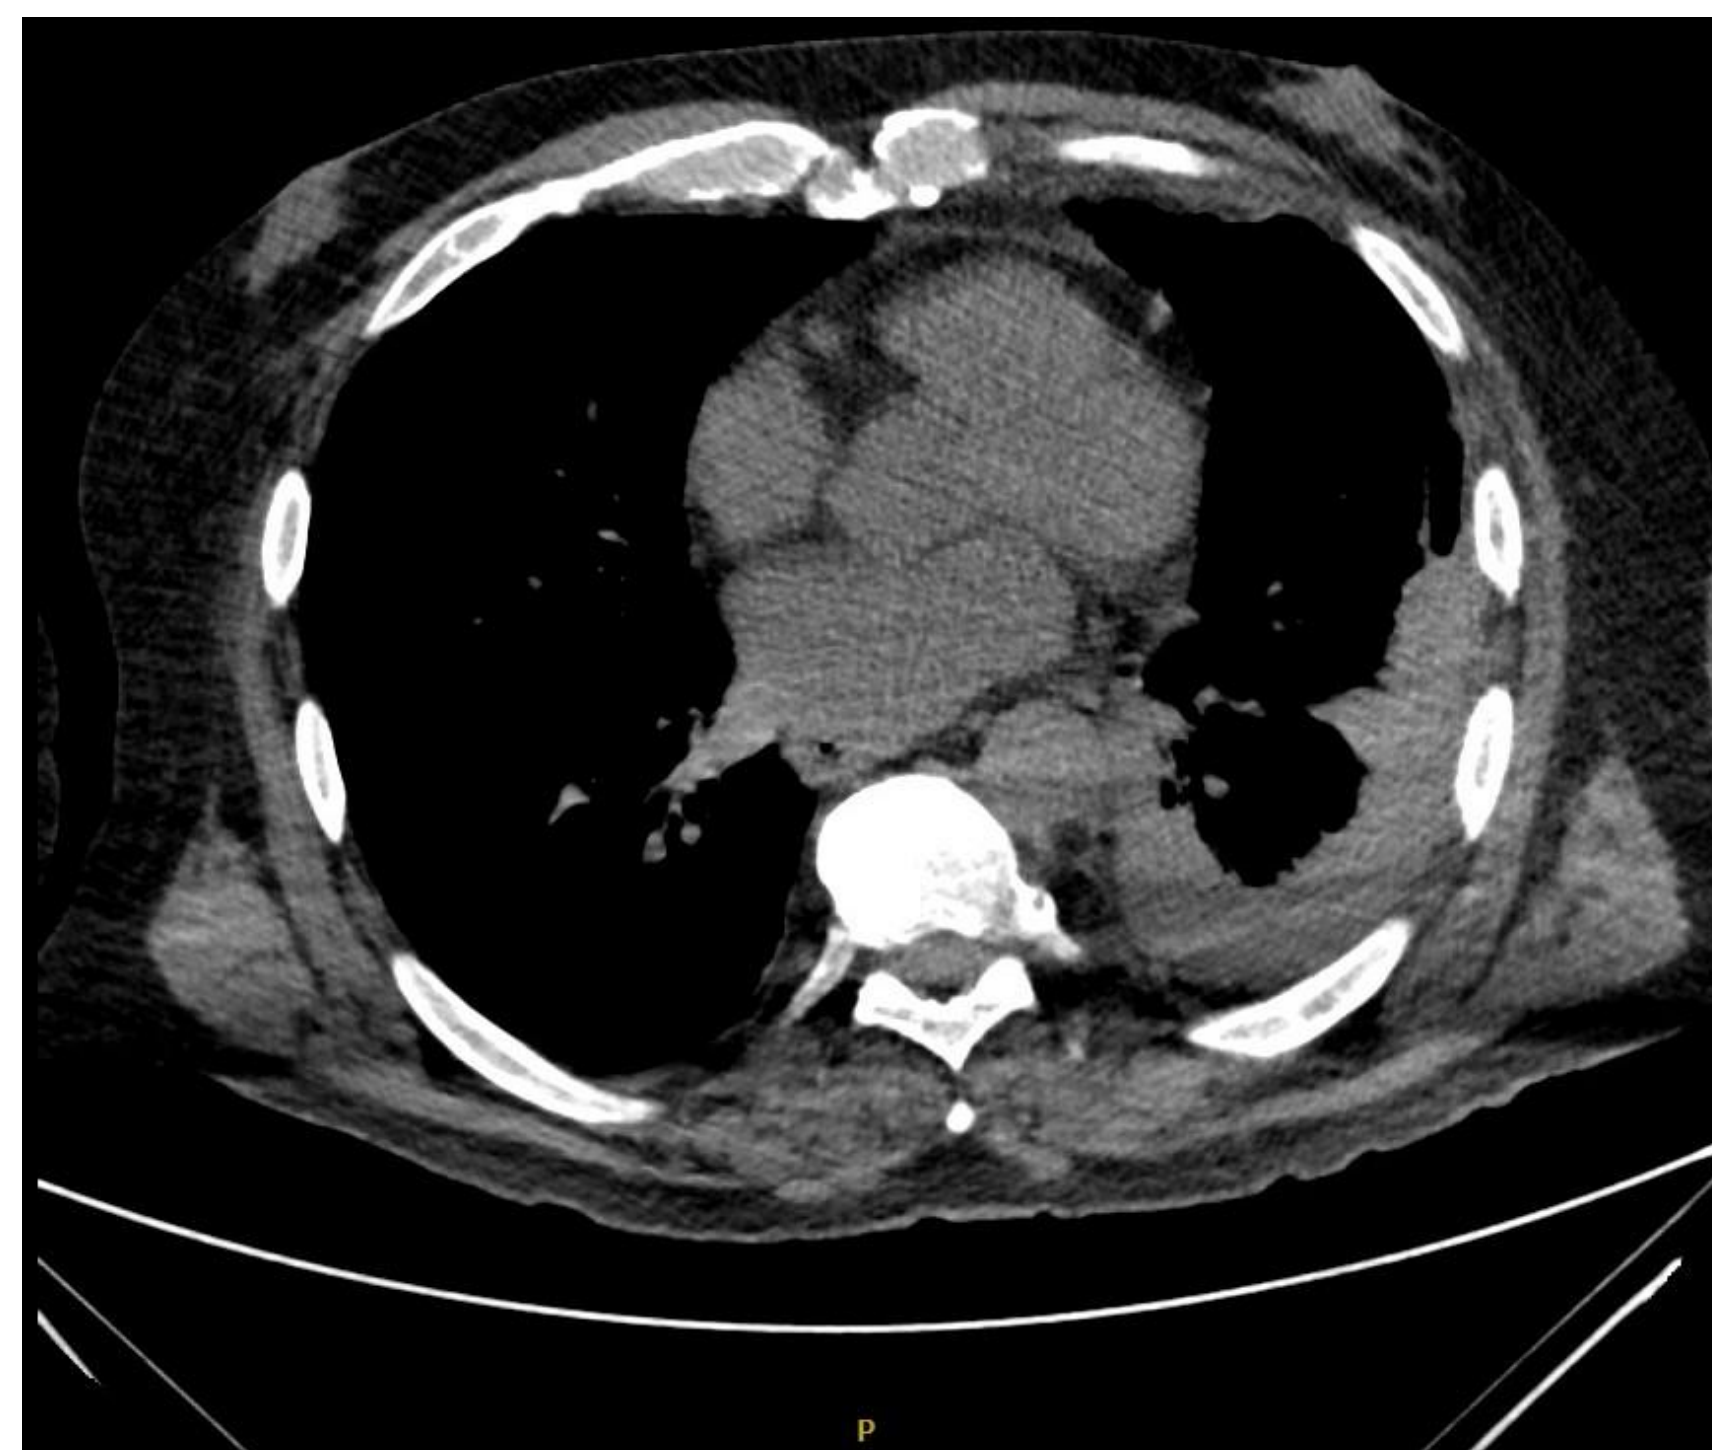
CT Chest 1 Week after Treatment on Day 10
